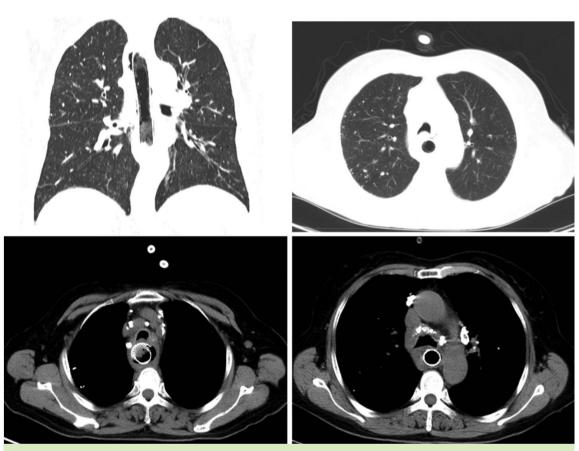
CT scan of esophageal stent shadow, esophageal wall thickening, multiple small nodules, patchy shadows, and mediastinal and lung door multiple calcified lymph nodes.
